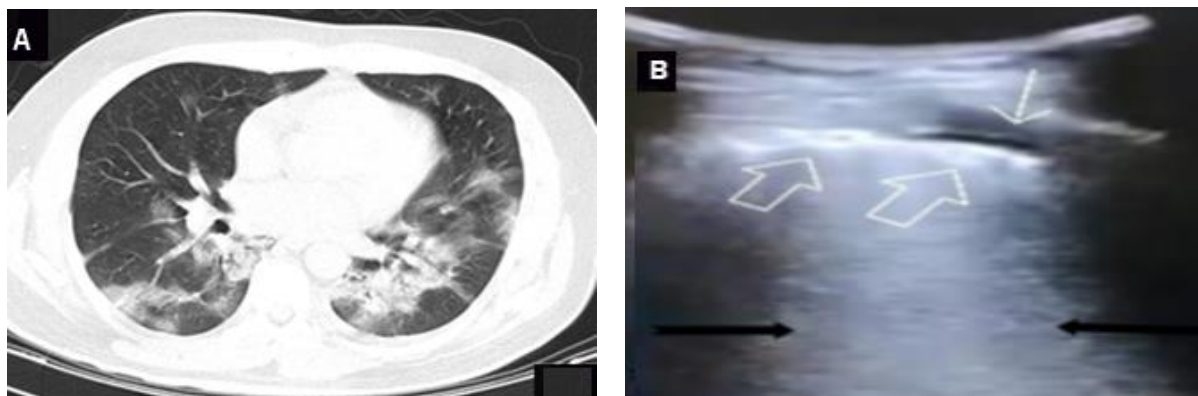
(A) Central, peri-bronchovascular consolidation and GGO in the CT scan. (B) US with pleural irregularity (open arrows) and mild pleural effusion (thin white arrow) and the B₂ lines (between the black arrows). GGO: Ground Glass Opacity.
